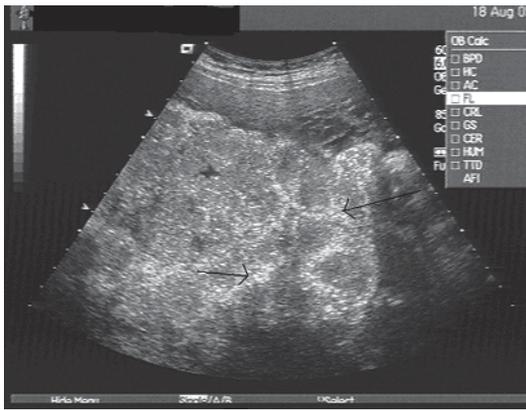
Prenatal sonographic image of the placenta of a patient with pseudoxanthoma elasticum showing extensive calcification.
